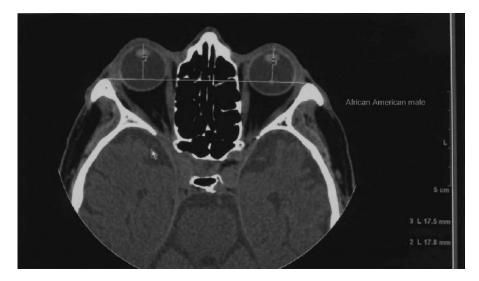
Computed tomography of the orbits of an African-American patient. The vertical lines represent the distance between the cornea and the lateral orbital rim.
